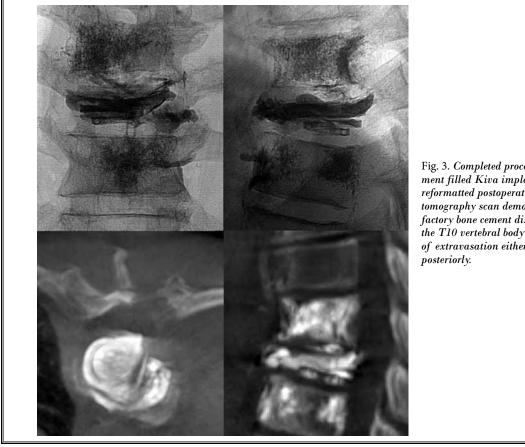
Completed procedure with cement filled Kiva implant. X-ray and reformatted postoperative computed tomography scan demonstrating satisfactory bone cement distribution within the T10 vertebral body and the absence of extravasation either anteriorly or
